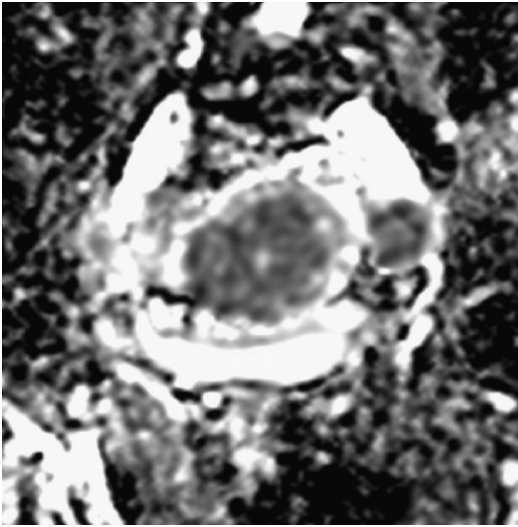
DWI. Coronal oblique plane, perpendicular to the uterine cavity. Endometrium carcinoma staging. Note diffuse myometrium invasion.
